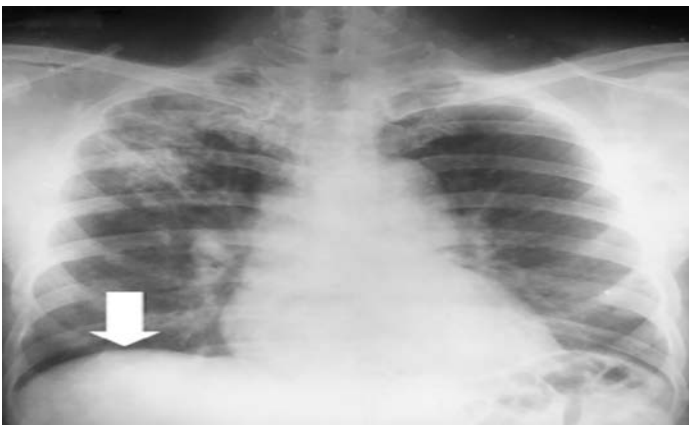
Chest radiograph taken after 24 hours showing resolution of pneumoperitoneum pointed by the white block arrow without the radiolucency under
